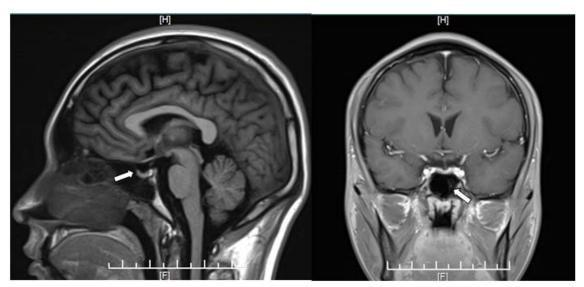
MRI of the empty sella (Sagittal and Coronal images after contrast medium administration)
